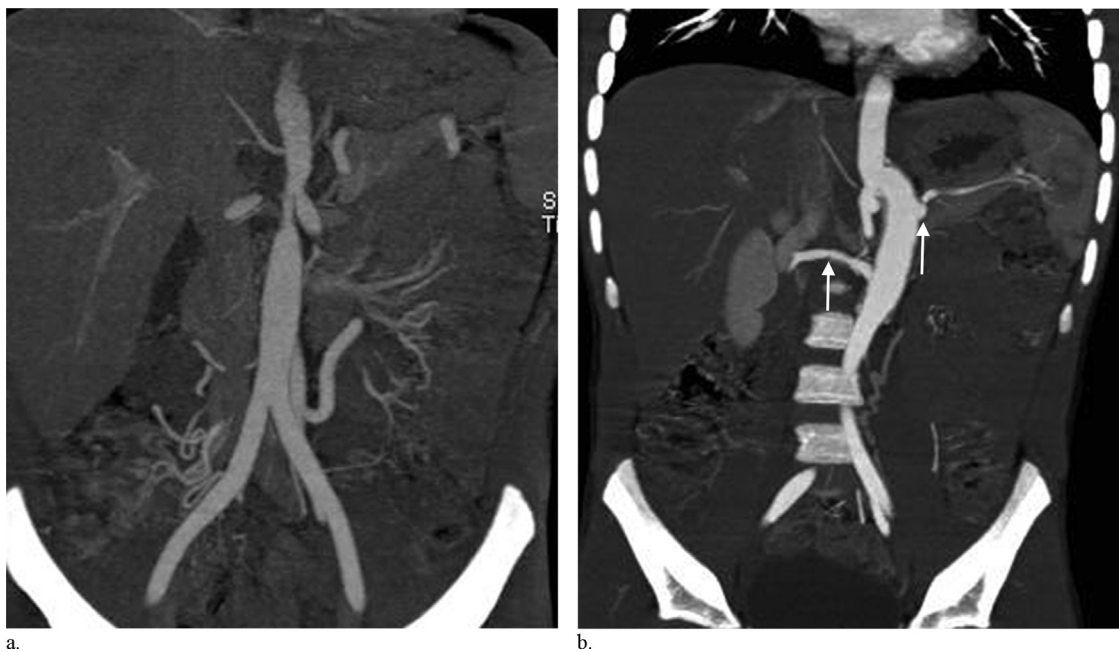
CT angiography. (a) Maximum intensity projection image demonstrates mid-aortic stenosis before surgical bypass. (b) CT coronal reformat after aortic bypass graft demonstrates end-to-end anastomosis of renal arteries with extension grafts (arrows) sewn into the bypass graft.
